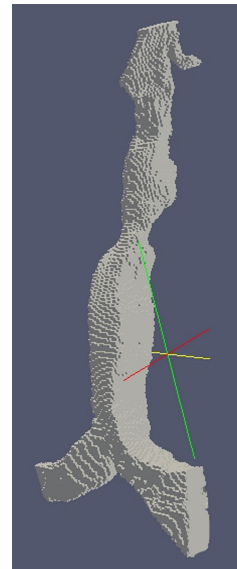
External airways reconstruction from CT scan. The stenosis is clearly visible.
